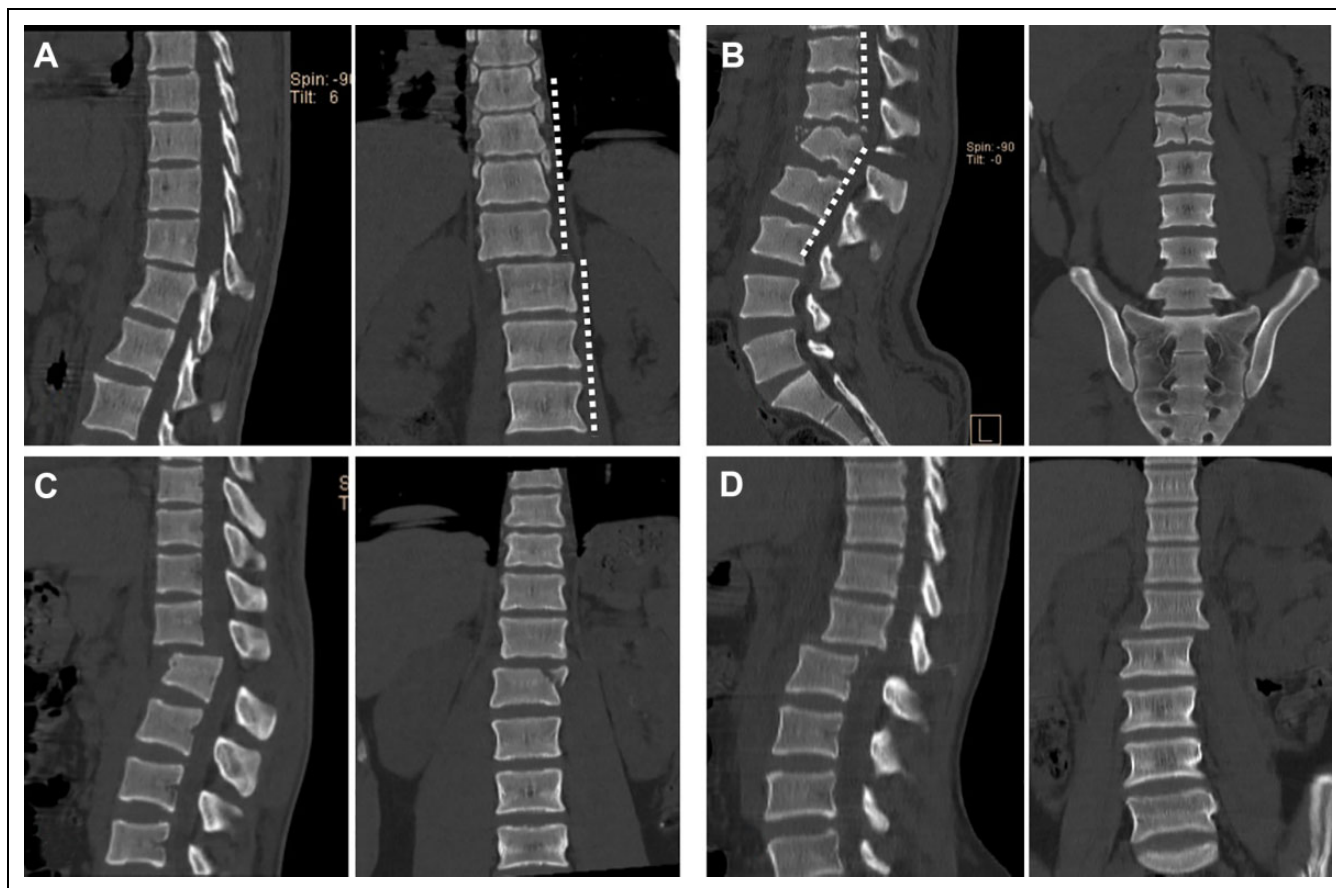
Classification of TLFD with intact neurology: (A) the coronal section indicates coronal translation (type 1); (B) the sagittal view indicates the presence of sagittal translation (type 2); (C, D) the coronal and sagittal CT images indicate the presence of combined translation in both the planes, anterior (type 3a) (C) and posterior (type 3b) (D).
